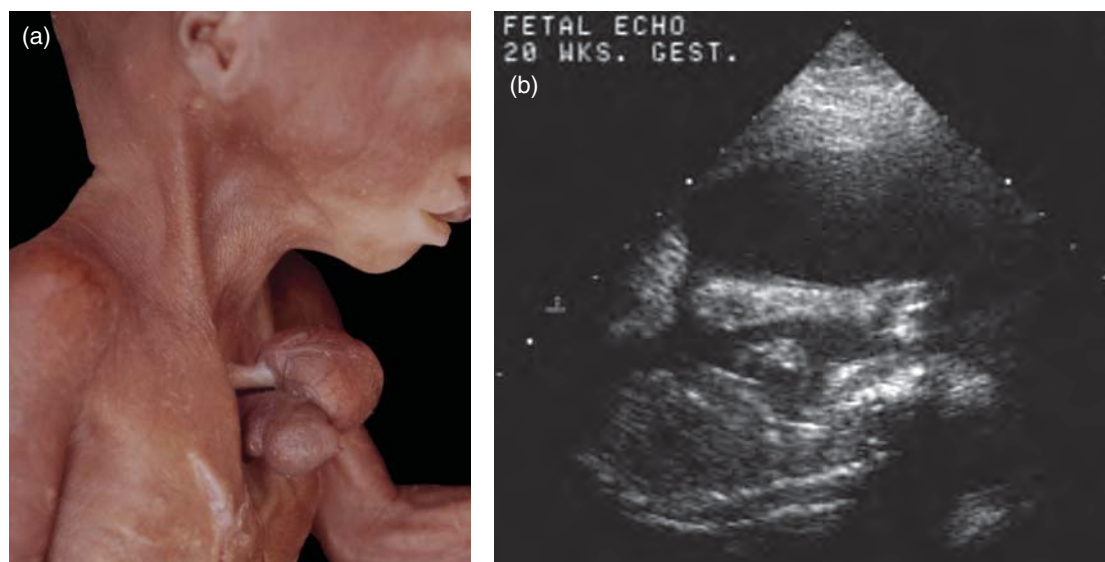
(a) Thoracocervical ectopia cordis in a 20 weeks' gestation fetus. There is a defect in the superior portion of the sternum. There is cephalic orientation of the cardiac apex and complete absence of the parietal pericardium. Double outlet right ventricle and left ventricular hypoplasia were present. Extracardiac defects were also present as evidenced by the bilateral cleft lip and palate. Chromosome analysis was normal. (Image courtesy of William D. Edwards). (b) Fetal echocardiogram demonstrating the findings noted in (a) with thoracocervical ectopia cordis.
